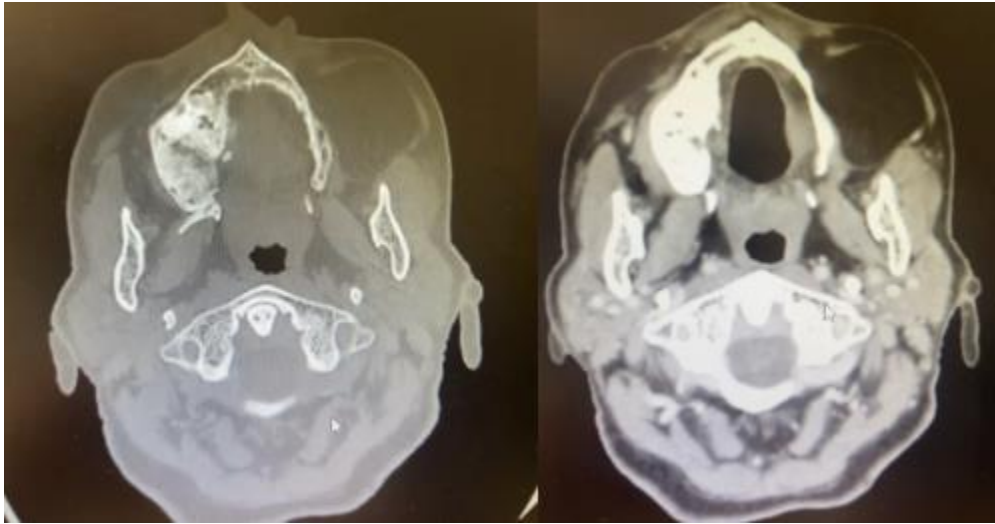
Axial computed tomography images demonstrating a well-circumscribed homogeneous lipomatous lesion occupying the left jugal and masticatory region, without significant enhancement after contrast administration, consistent with an intra-jugal lipoma
